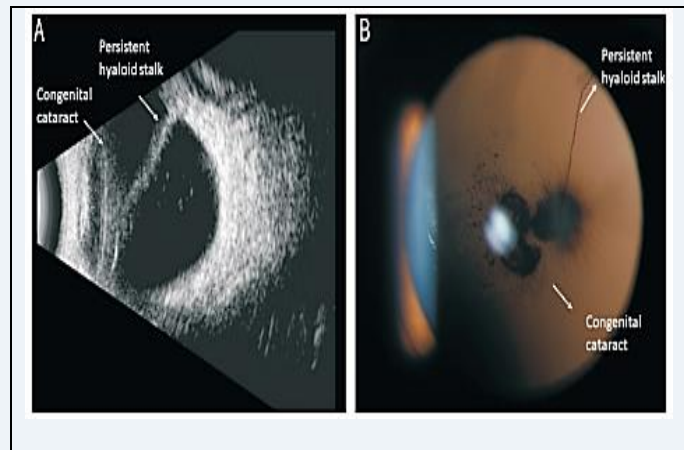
Characteristics of patients with CC and PFV in this study A: Ultrasonography showing congenital cataract combined with a persistent hyaloid stalk extending from the optic disc attached to posterior capsule; B: Slit-lamp image showing congenital cataract combined with a persistent hyaloid stalk.
